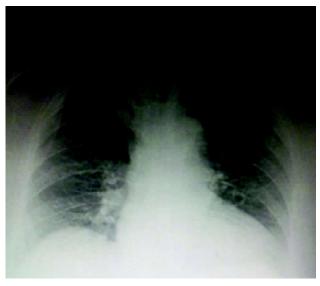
X-ray chest (PA view) showing right paratracheal opacity.
